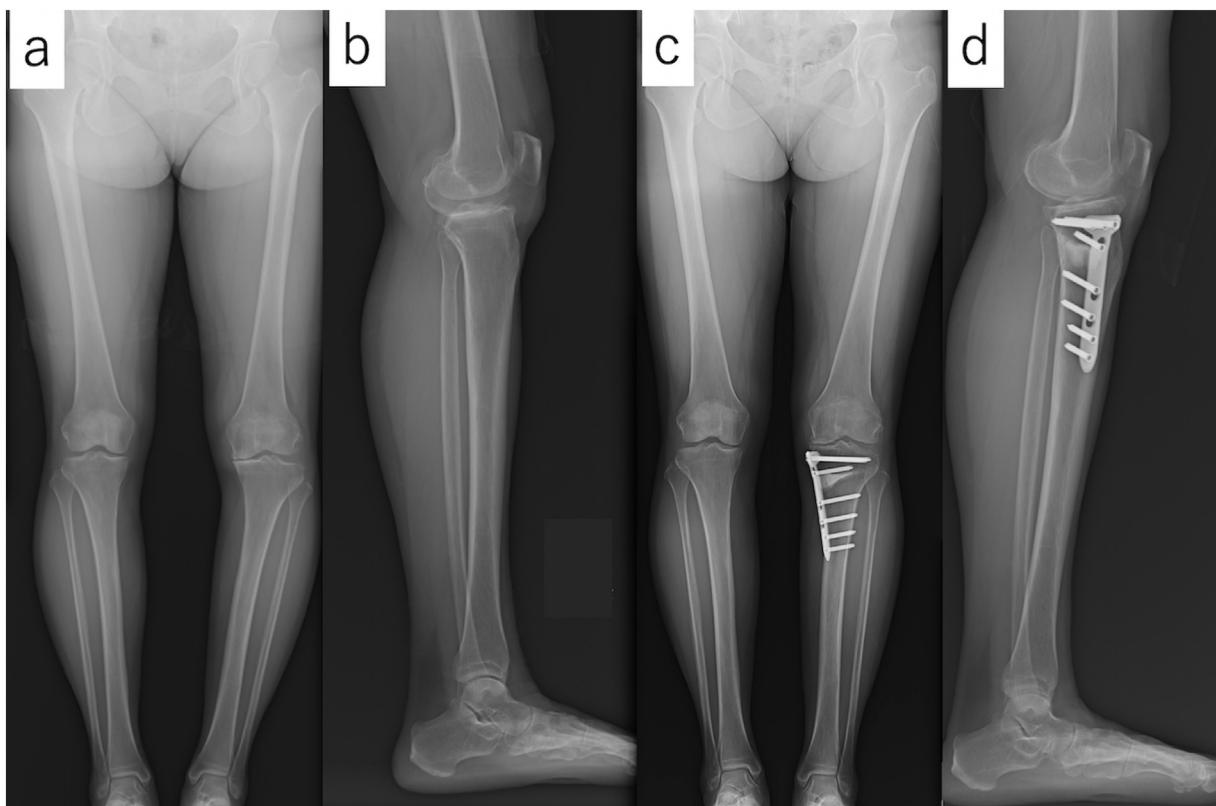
Whole leg radiographs before (a,b) and after (c,d) the first surgery.
